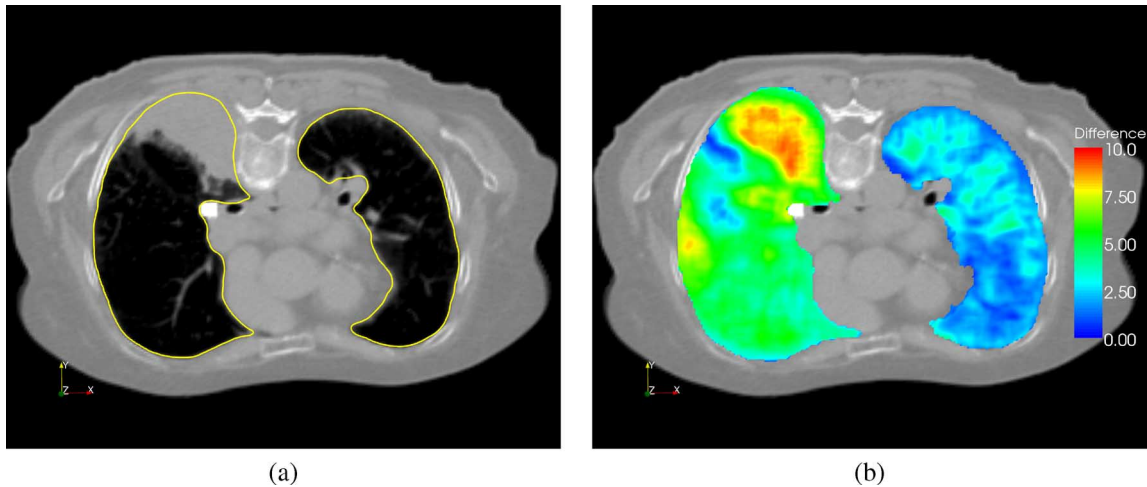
Difference between lung motion estimated by patient-specific registration and lung motion predicted by the 4D-MMM. (a) CT slice of patient 10 with lung contour (yellow) and tumor adhering to the posterior chest wall. (b) Magnitude of the difference between the individual motion field computed by intra-patient registration and the model-based predicted motion field for this slice. Left lung shows intact lung motion, dynamics of the right lung is impaired by the large tumor.
